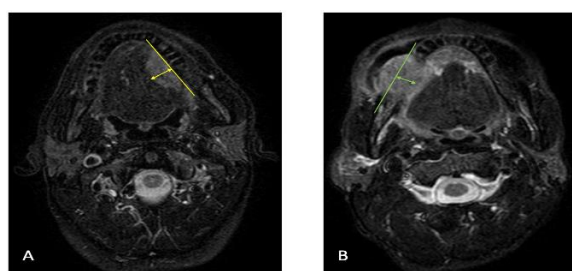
Axial STIR MRI section of Tongue squamous cell carcinoma showing DOI measurement. Solid yellow line represents the radiological plumb line. MRI measured DOI in shown in yellow arrows.
